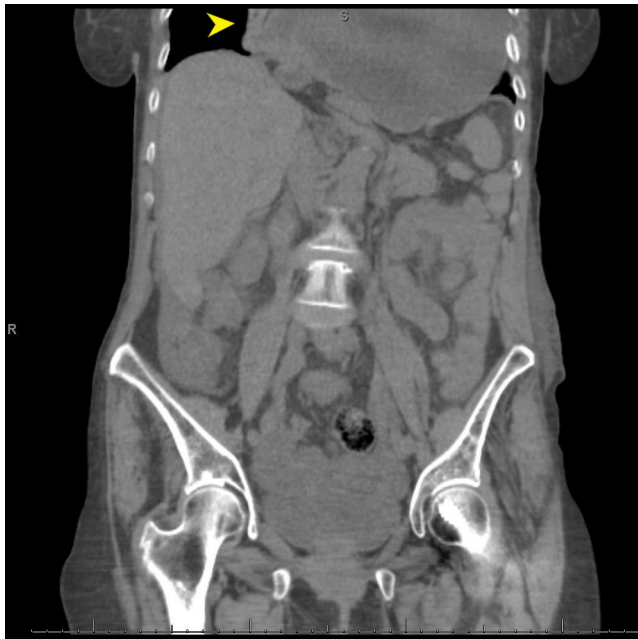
CT abdomen reveals complete herniation of the stomach into the posterior mediastinum (arrows).
